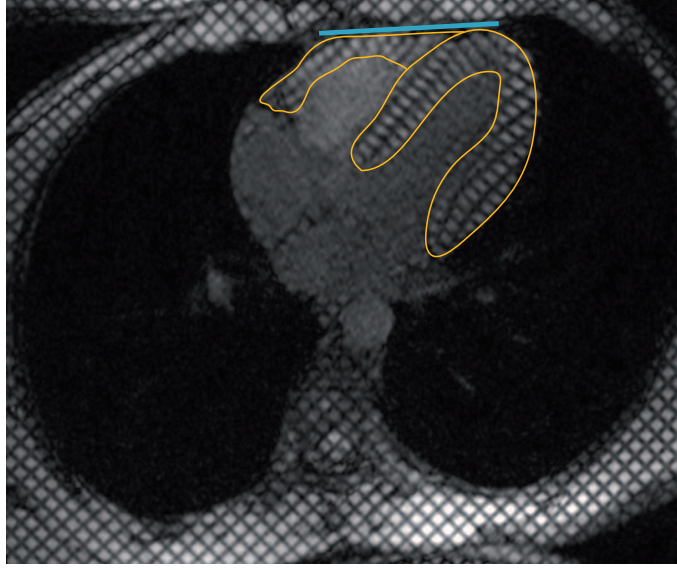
Surfaces designated for the contact boundary conditions are obtained using Cine MRI (or tagged Cine MRI, as in this case).
